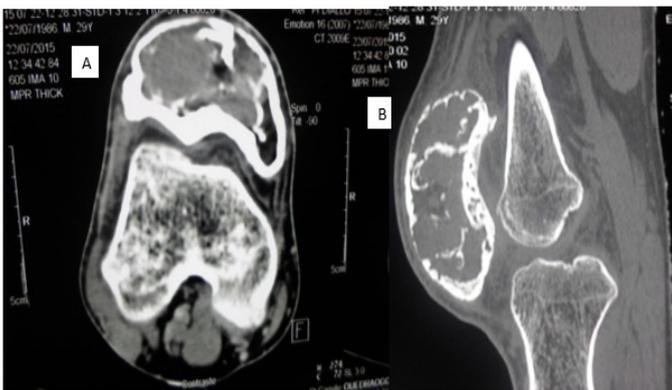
CT, Coronal (A) and sagittal (B) view of the patella and femoral condyles, showing the septate aspect and the matrix.
